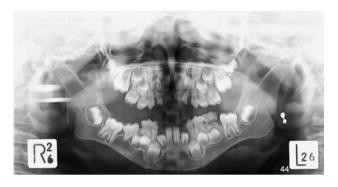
DPT radiograph aged 7 years
